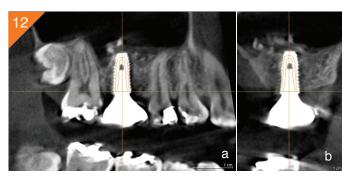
a) A CBCT lateral view of the 1 year post-operatory check after the surgery. b) A CBCT cross-sectional view of the 1 year post-operatory check after the surgery.
